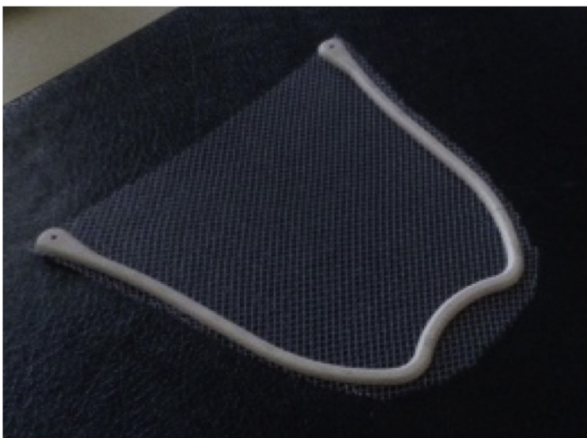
shows the design of the SRM: the device is composed of a solid frame in the shape of a parallelogram consisting of a ventral arch with a midline incision for the urethra and two lateral arms ending with two dorsal tips. In between an ultra-light mesh is stretched and connected to the frame using an ultrasonic technology.
